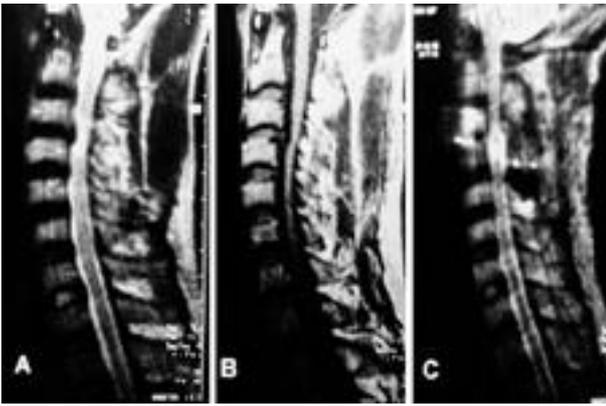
71-year-old man. A. preoperative sagittal T2-weighted MRI showed high signal area. C. postoperative sagittal T2-weighted MRI showed no signal change.
